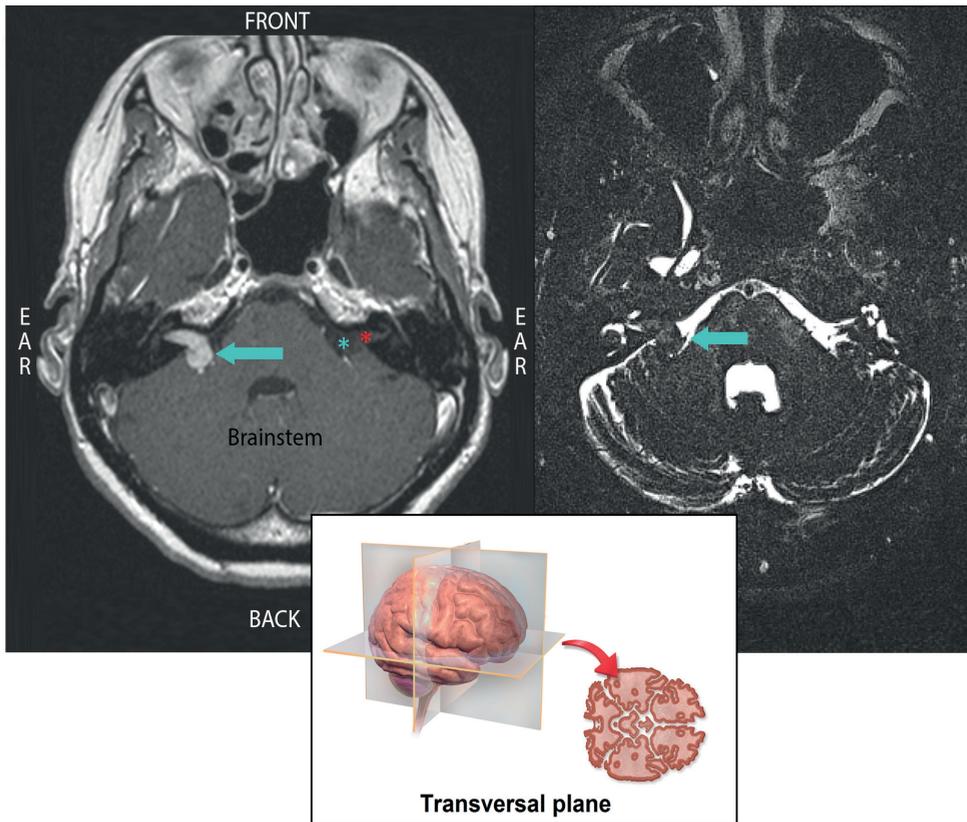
Example of a right-sided VS as seen on contrast-enhanced T1-weighted MRI (left) and high resolution T2-weighted MRI (right).
